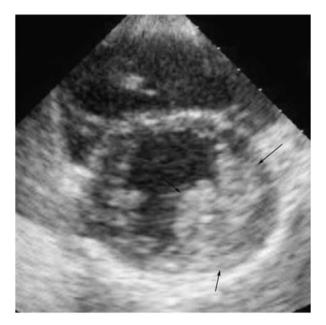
Parasternal short-axis projection demonstrating the mass involving the left ventricular free wall.
